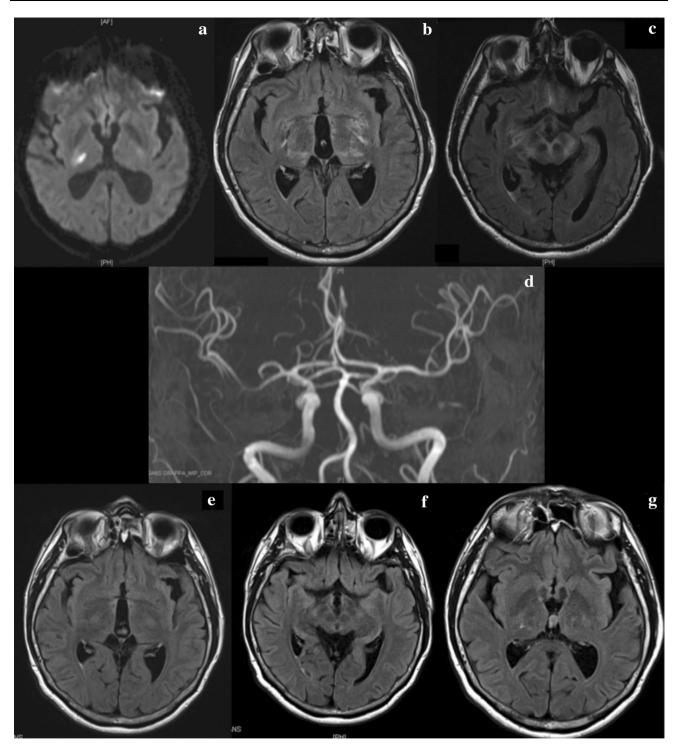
Case 2 Initial brain MRI (a, b, c). a Axial diffusion-weighted image: high signal intensity lesion on DWI with low ADC value (not shown) in the right posterolateral thalamus, suggestive of an acute infarct. b, c Axial Flair images: high signal intensity lesions in the thalami, the bilateral posterior limb of the internal capsules (b), the cerebral peduncles (in particular in the left substantia nigra) (c), consistent with chronic vascular lesions. d MR angiography, coronal view: mild narrowing of the distal M1 segment of the right middle
